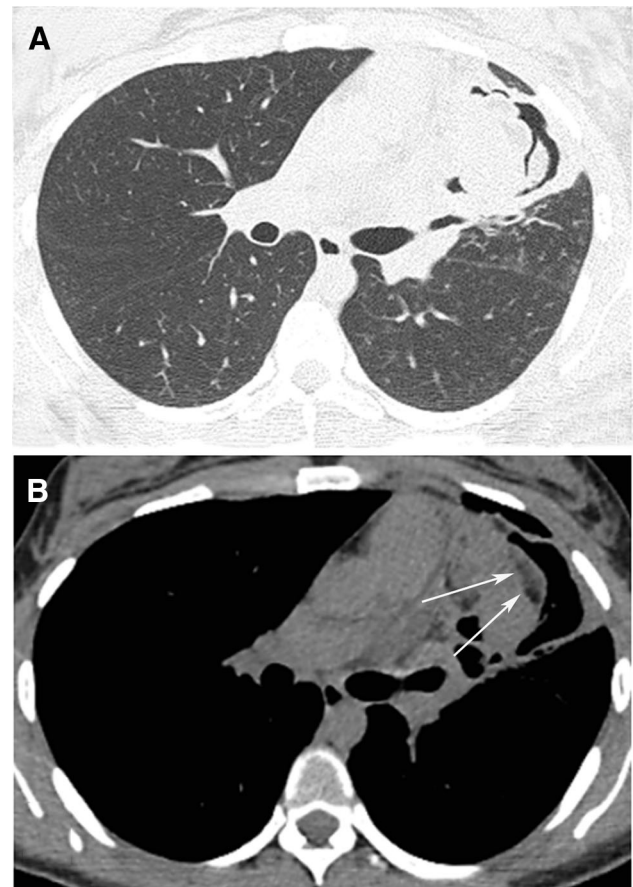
Teratoma. A 22-year-old woman presented with a history of cough and hemoptysis. Axial chest CT images obtained with the lung (a) and mediastinal (b) window settings reveal a thick-walled cavity in the left upper lobe, adjacent to the mediastinum, with an intracavitary mass (asterisk) and the air crescent sign. Note that the solid content presents focal areas of fat density (arrows in b)
